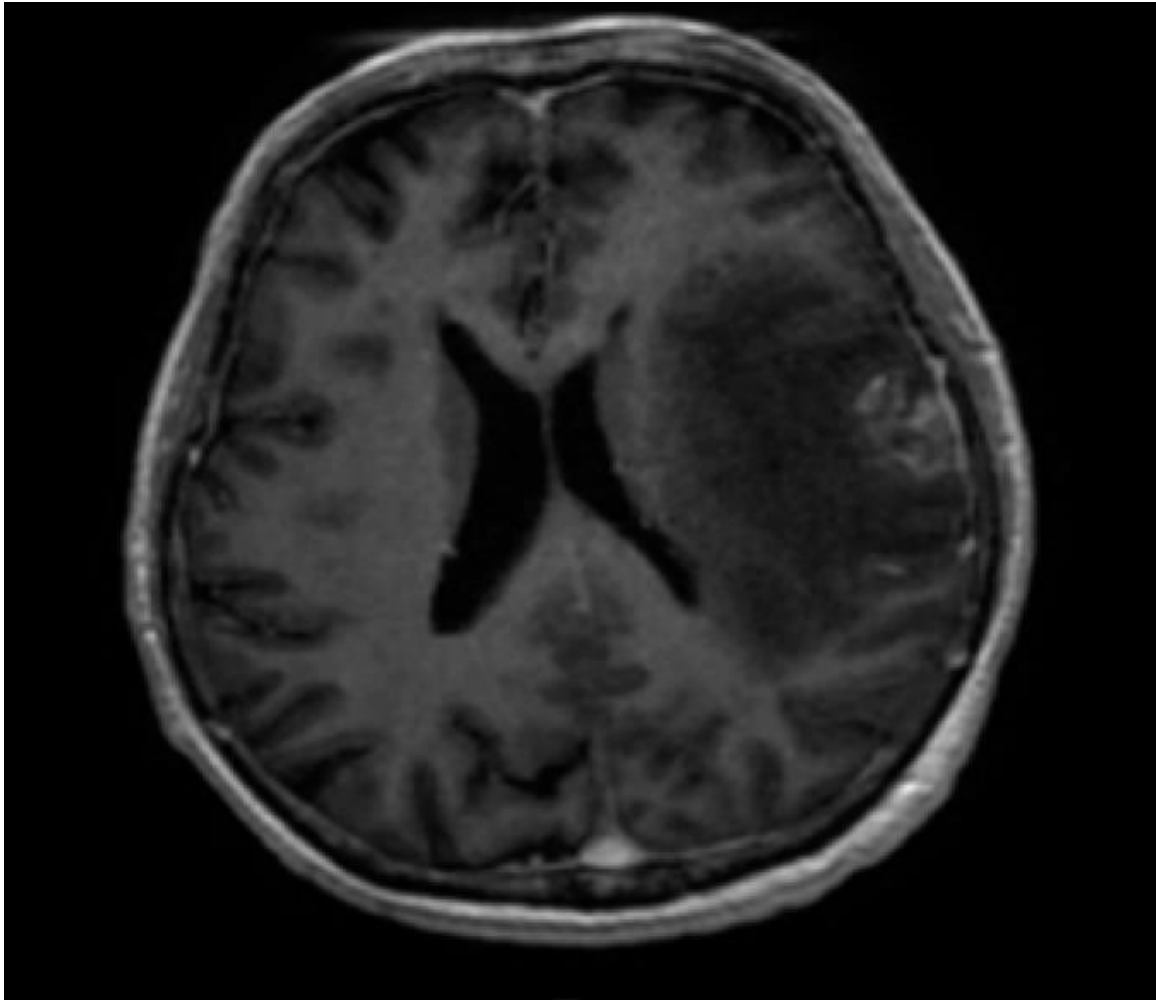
MRI of the brain, T1W post gadolinium, on axial plane at the level of lateral ventricle shows solitary inhomogeneous enhancing mass at the left frontal lobe with marked perilesional edema causing mass effect compressing onto the ipsilateral lateral ventricle. Thick irregular nodular leptomeningeal enhancement of the adjacent meninges present.
